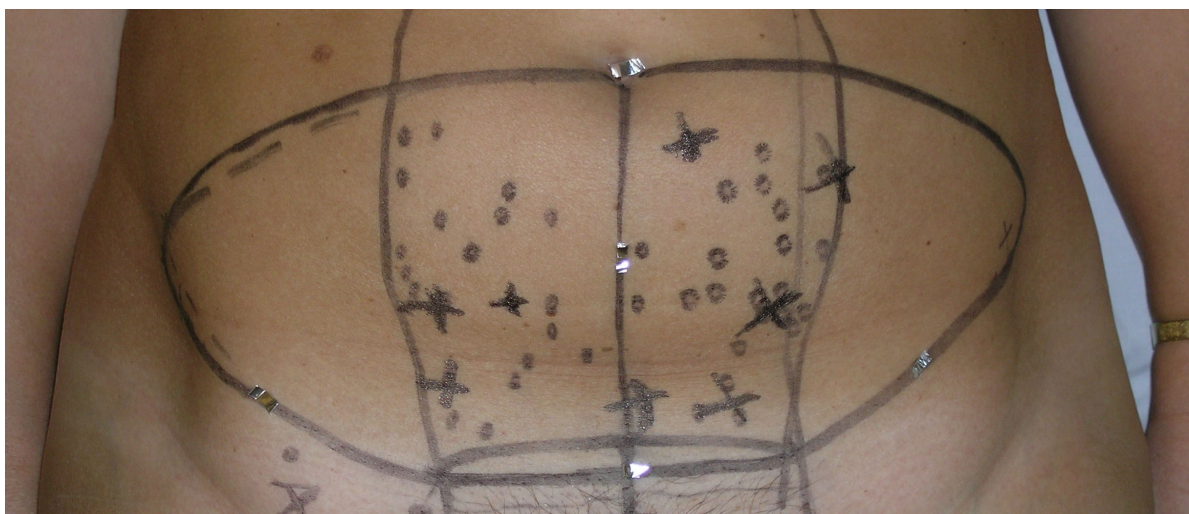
Hot spots associated with arterial Doppler sounds marked with crosses.
